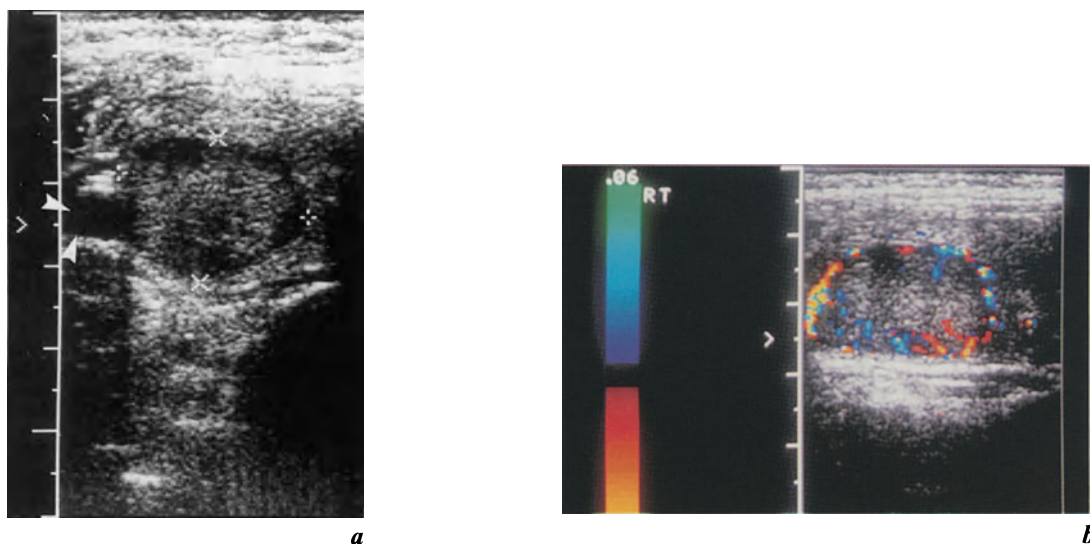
Gray scale ultrasound image of a follicular adenoma within the right lobe of the thyroid gland (arrowheads = common carotid artery). The nodule is encircled by a thin hypoechoogenic margin, the so-called “halo”
